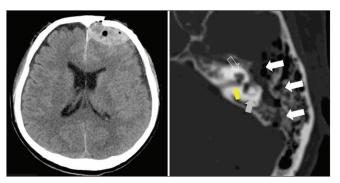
Preoperative CT showed left frontal epidural hematoma and temporal bone fracture (white arrow). The yellow, open white, and gray arrows indicate the internal auditory canal, cochlear, and lateral semicircular canal, respectively.
